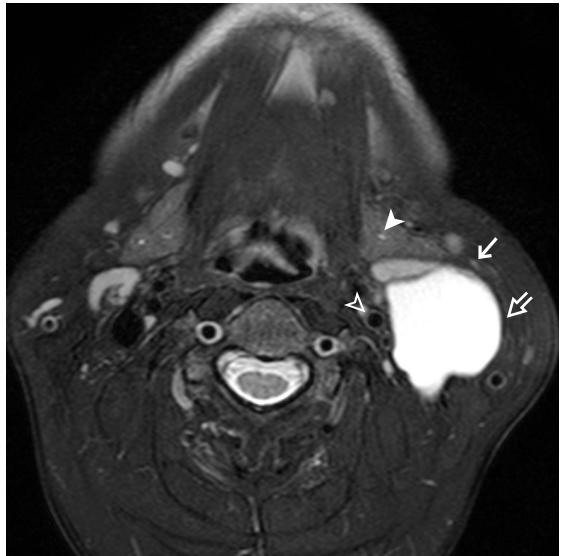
Axial T2W MRI of neck shows a well circumscribed lobulated cystic lesion (→) at the left upper neck, located posterior to the submandibular gland (▲), lateral to the carotid vessel (△) and along the anterior border of sternocleidomastoid muscle (⇨). The location and cystic nature are characteristic for a 2nd branchial cleft cyst.
